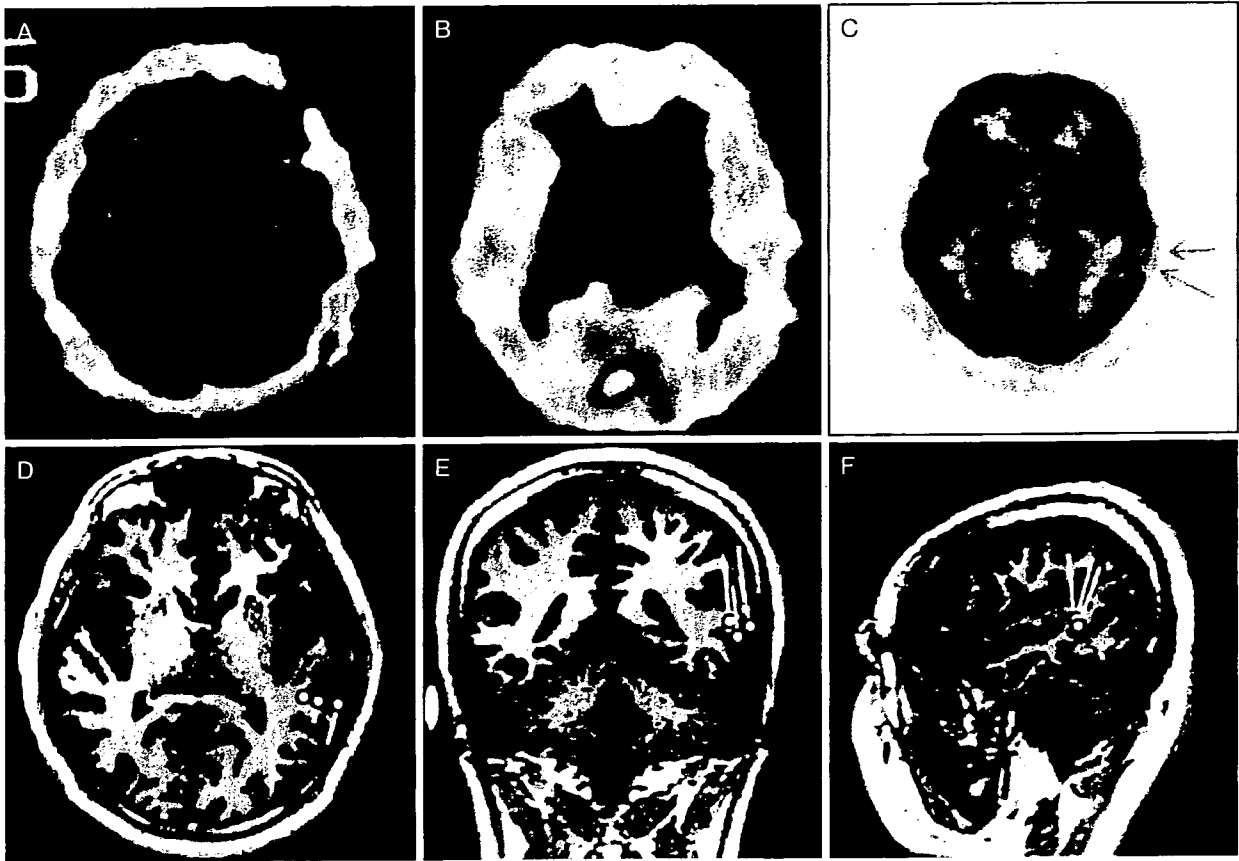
SPECT, PET and MEG
